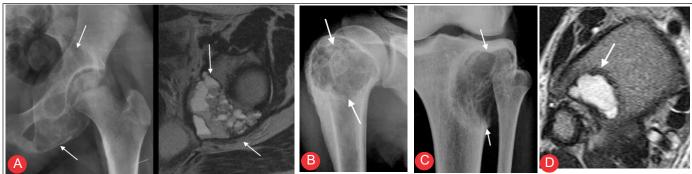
(a-d)Differential diagnosis. Frontal radiograph and axial magnetic resonance imaging (MRI) of the left hip (a) shows an aneurysmal bone cyst (arrows) with an expansile, trabeculated lesion on the plain radiograph and complete fluid-fluid levels on the MRI. Plain radiograph (b) of the right humerus shows a large chondroblastoma (arrow) in the epimetaphysis with sclerosis and periosteal reaction. Plain radiograph (c) of the left tibia shows a trabeculated, expansile lesion (arrows) not reaching up to the articular surface. Axial T2W MRI (d) of the ankle shows a tibial ganglion cyst (arrows).
